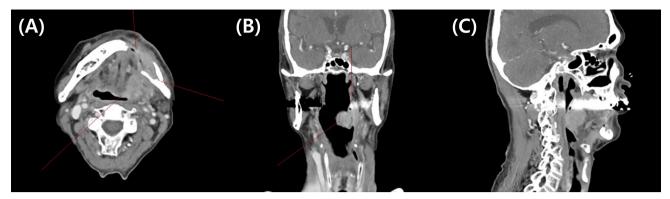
Enhanced CT view of Case 1 patient shows recurrent squamous cell carcinoma (red indicators) in the oropharyngeal wall, tongue, left mandible and maxilla, resulting in narrowing of the airway space. (A) Axial view, (B) Coronal view, (C) Sagittal view. CT, computed tomography.
